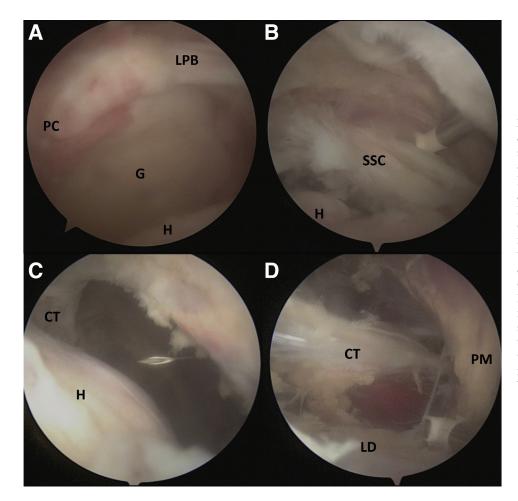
Exploration and anterior and inferior dissection (right shoulder with patient in beachchair position; visualization from lateral portal in A and from anterolateral portal in B-D). (A) Exploration of irreparable massive cuff tear. (B) Anterior debridement of remaining subscapularis tendon (SSC). (C) Anterior and anterolateral portal for further dissection of latissimus dorsi. (D) Exposure of latissimus dorsi (LD): inferior dissection below subscapularis and posterior to pectoralis major (PM) and conjoint tendon (CT). (G, glenoid; H, humerus; LPB, long portion of biceps; PC, posterior cuff tear.)
